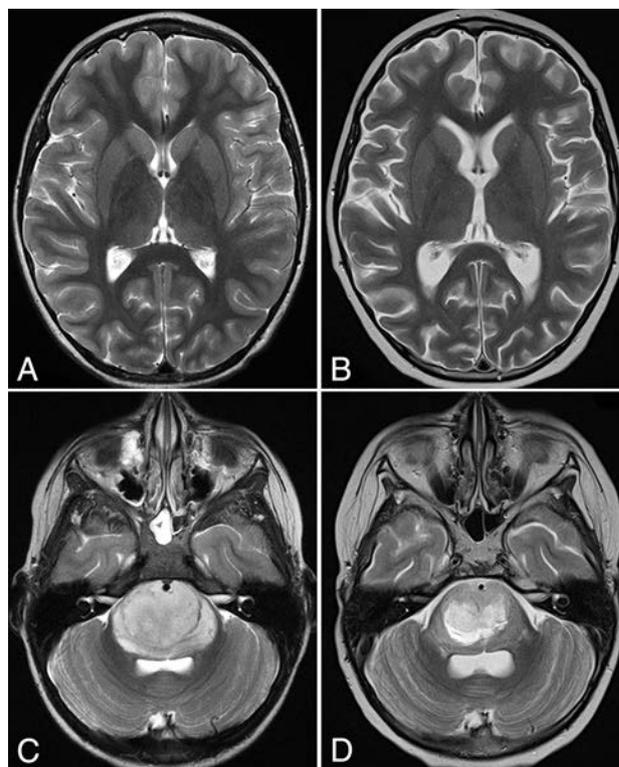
Axial T2-weighted images of the supratentorial brain (A and B) and brain stem lesions (C and D) in a patient with DIPG at baseline (A and C) and after RT (B and D). D, Note the prominent brain stem lesion volume reduction in conjunction with less robust but measurable pseudoatrophic changes within the supratentorial brain parenchyma.
